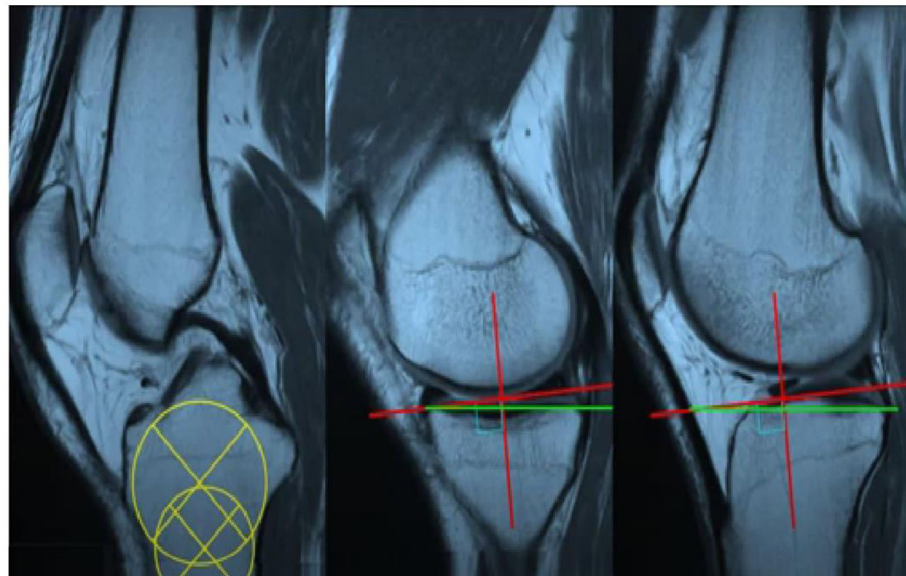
Measurement of Tibial Slope on MRI.
